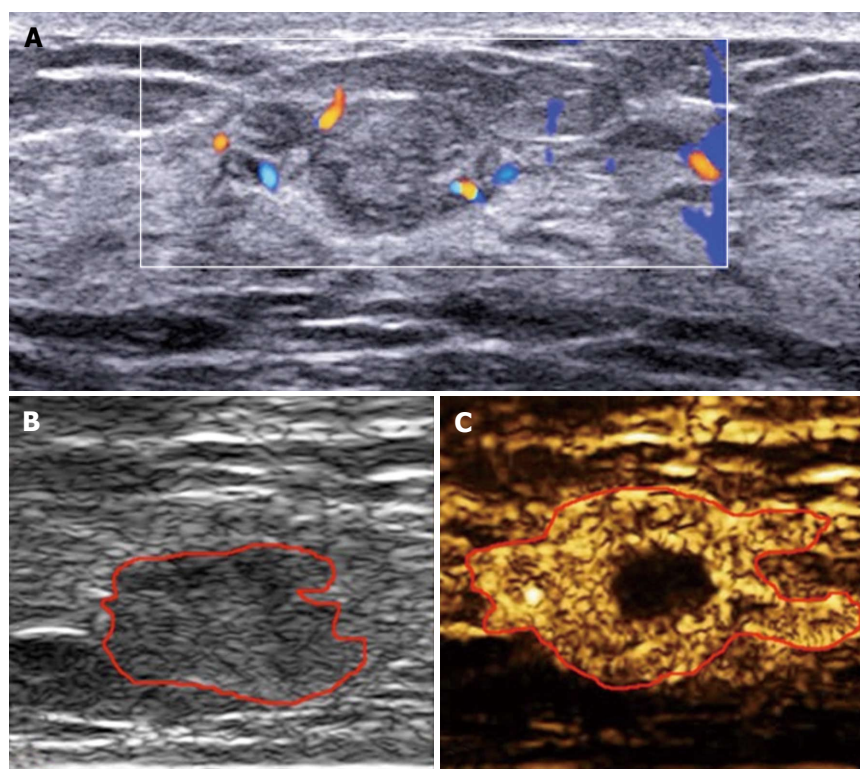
Enhancement patterns of inflammatory lesion. A: Color Doppler flow imaging with hyper-vascular; B: Heterogeneous hyper-enhancement with rapid wash-in, enlarged size compared with 2 dimensional image, with perfusion defect, irregular shape and unclear margin, without penetrating vessel and crab claw-like pattern.
